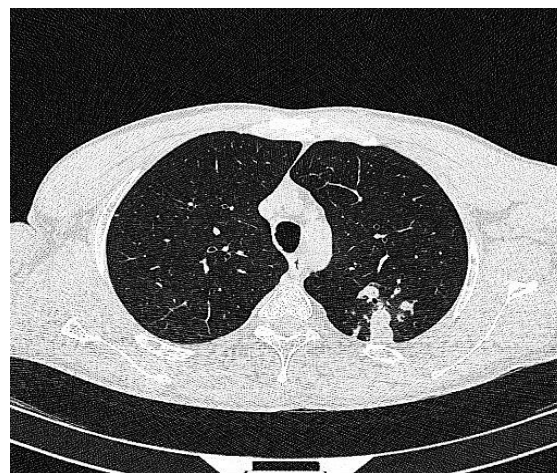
Case No. 2: lung computed tomography (CT) scan of the patient with clavicular fracture and incidental opacities on the chest x-ray (CXR) showing peripheral lung involvements in favor of coronavirus disease 2019 (COVID-19)
